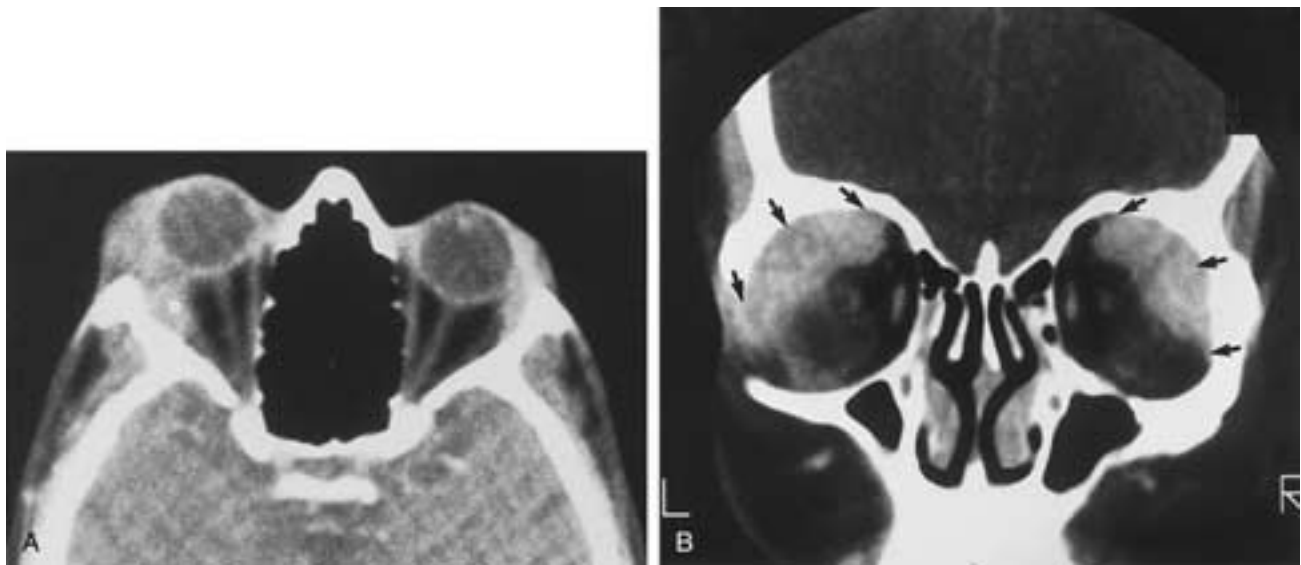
A, Sarcoidosis chronic dacryoadenitis. Axial CT scan shows enlargement of the right lacrimal gland. Note the mild enlargement of the left lacrimal gland. B, Sarcoidosis. Coronal-enhanced CT scan shows moderate enhancement of markedly enlarged lacrimal glands (arrows).
